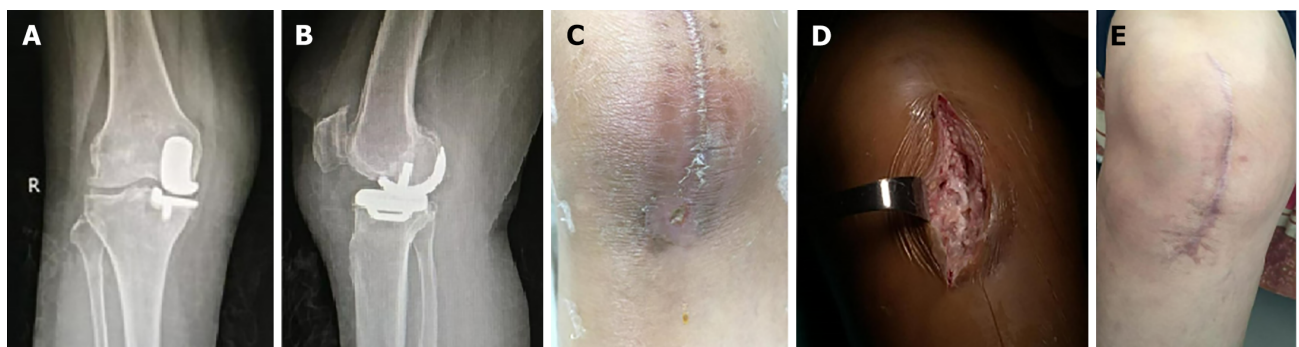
Treatment process (right knee) for Patient 1. A: Anteroposterior X-ray before revision; B: Lateral X-ray before revision; C: Surgical opening before revision; D: Incision for revision; E: The incision healed well after revision.
